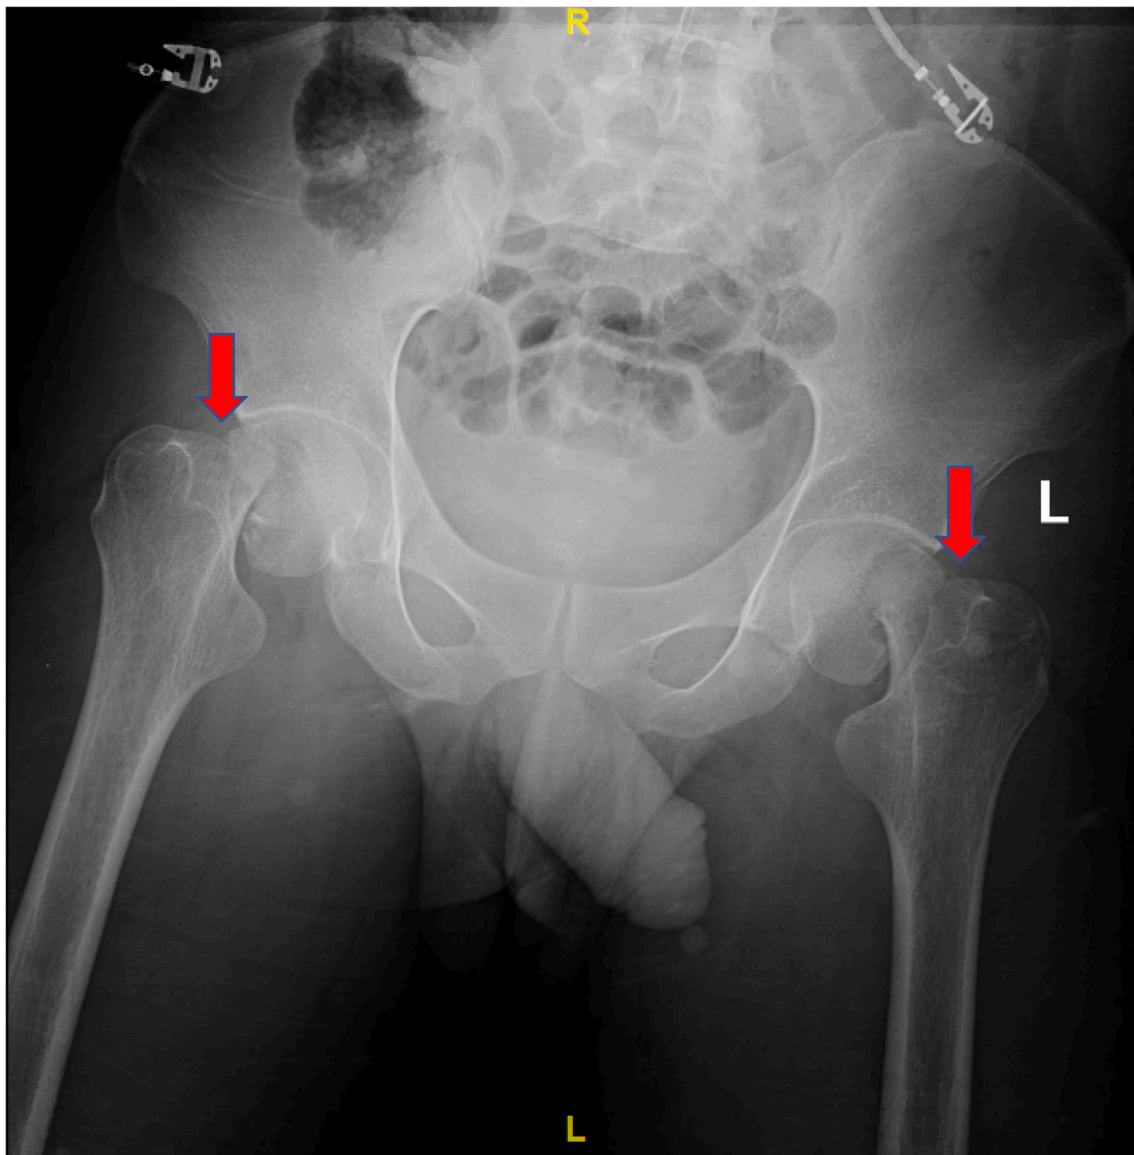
Pelvis X-ray completed during primary survey: bilateral subcapital femur fractures. Arrows are marking the bilateral fractures.
